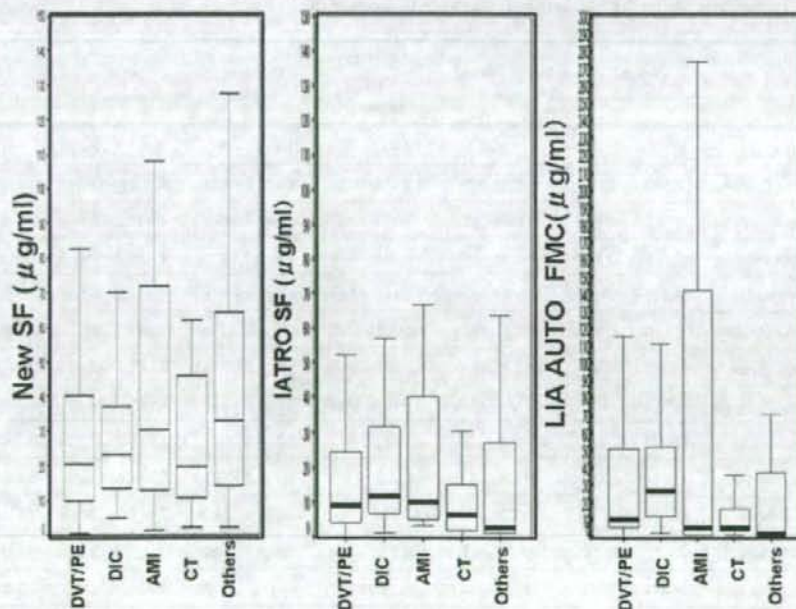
The plasma concentrations of New SF in patients with DVT/PE, DIC, cerebral thrombosis and other diseases. CT: cerebral thrombosis.
